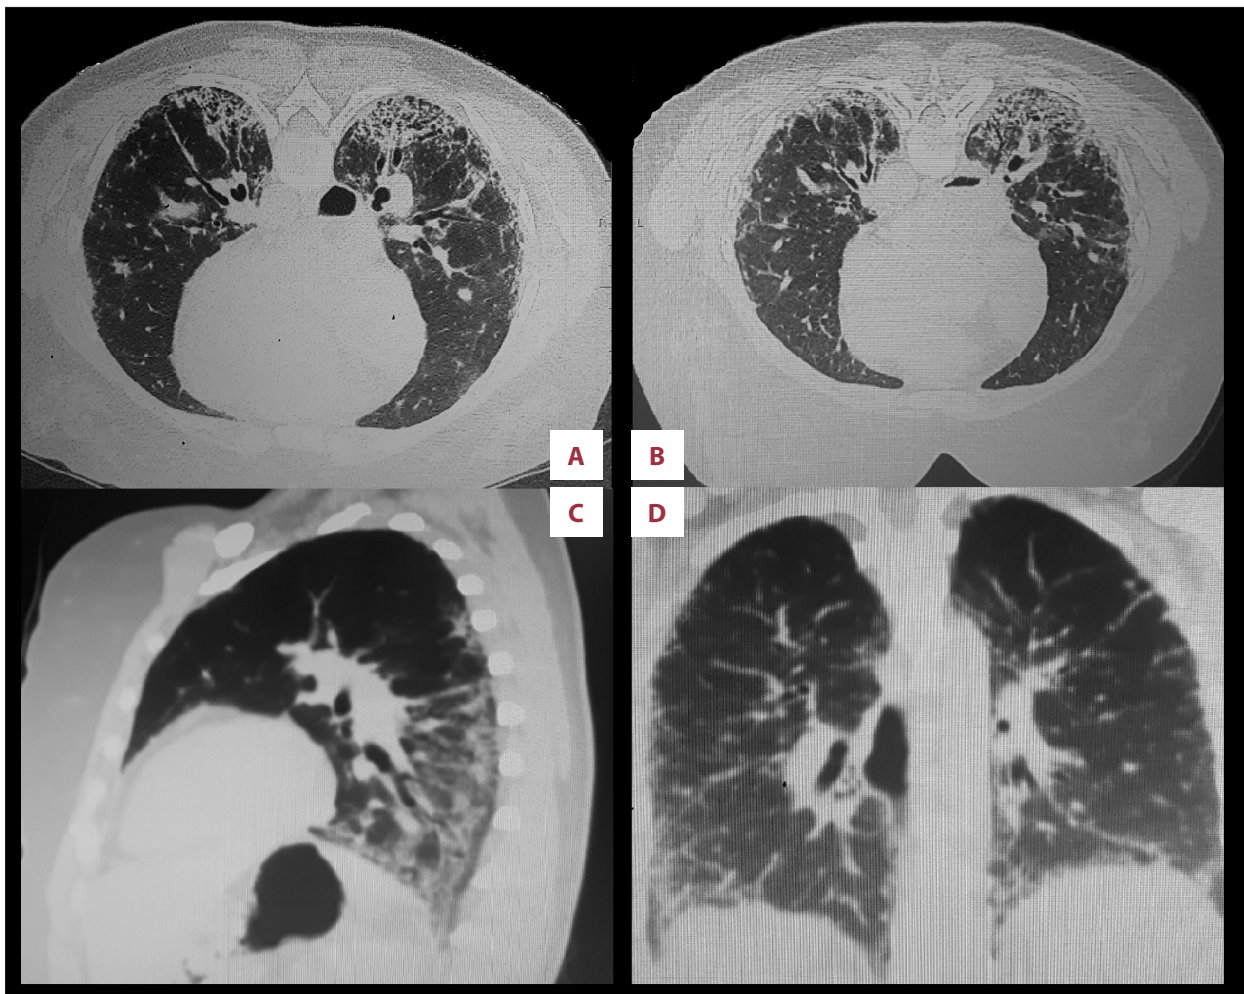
HRCT of the chest compatible with NSIP. Pulmonary fibrosis by peripheral and peribronchovascular reticular infiltrates, preserving the subpleural regions, with architectural distortion, associated with areas of ground-glass, bronchiectasis, and some honeycombing cysts. (A, B) Transverse incidence of the mid-lower chest with a 1-year difference between them. (C) Sagittal incidence. (D) Coronal incidence of the posterior chest.
